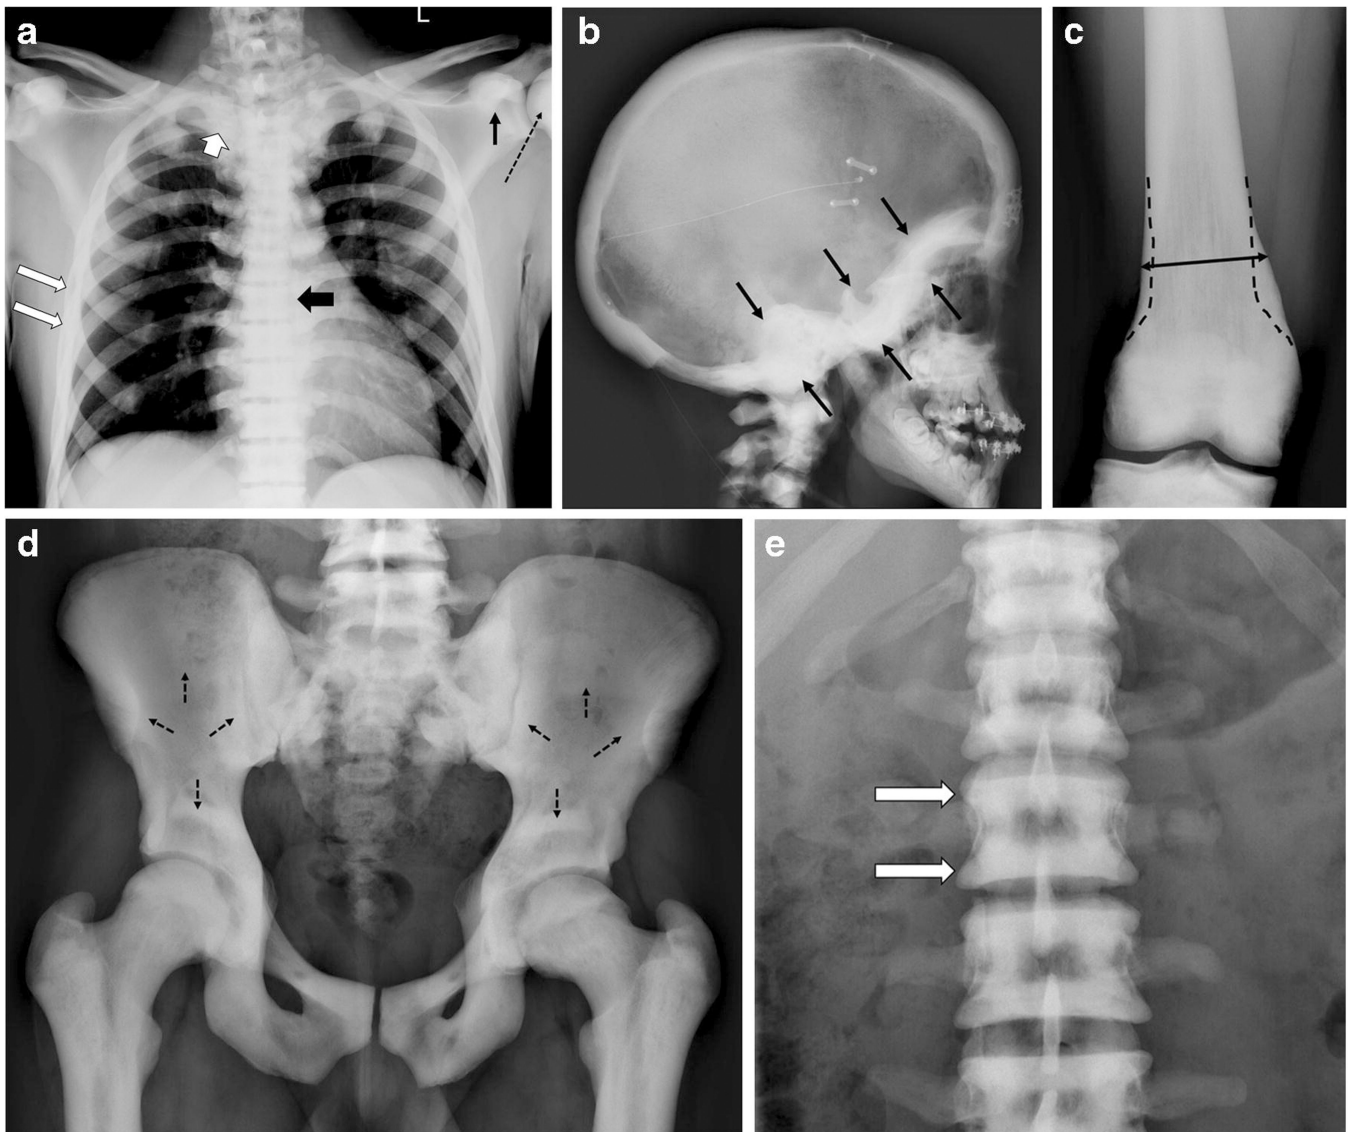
A young adult male with ADO2 demonstrates all classic radiograph features of the disease. (a) AP chest radiograph with diffuse sclerosis of the ribs (long white arrows), clavicles (short white arrow), vertebral bodies (short black arrow), coracoids (thin black arrow), and proximal humerus (dashed black arrow). (b) Lateral skull radiograph with skull base thickening (black arrows). (c) AP distal femur radiograph with Erlenmeyer flask deformity (abnormal width of distal femoral metadiaphysis, double headed arrow; expected shape of distal femur, dashed black line). (d) AP pelvis radiograph with endobone (bone-within-bone) appearance (dashed arrows). (e) AP lumbar spine radiograph with dense sclerotic bands at the vertebral body endplates (“rugger jersey” spine, white arrows).
